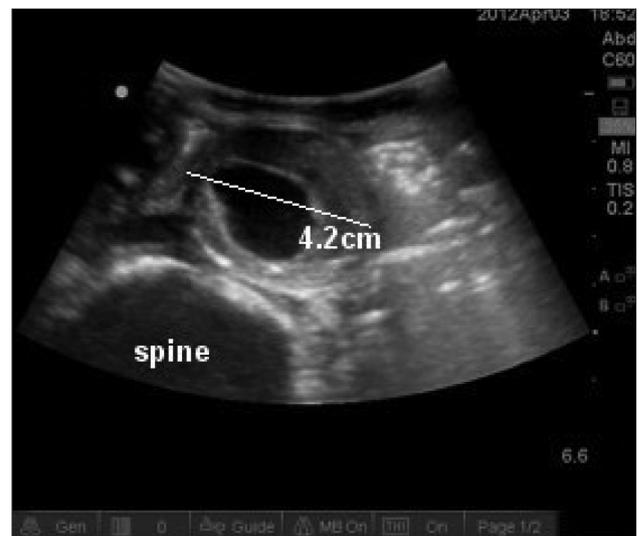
Ultrasound showing an abdominal aortic aneurysm measuring 4.2 cm, the widest diameter measured from wall to wall. Note the lumen is much smaller than the aortic diameter.
